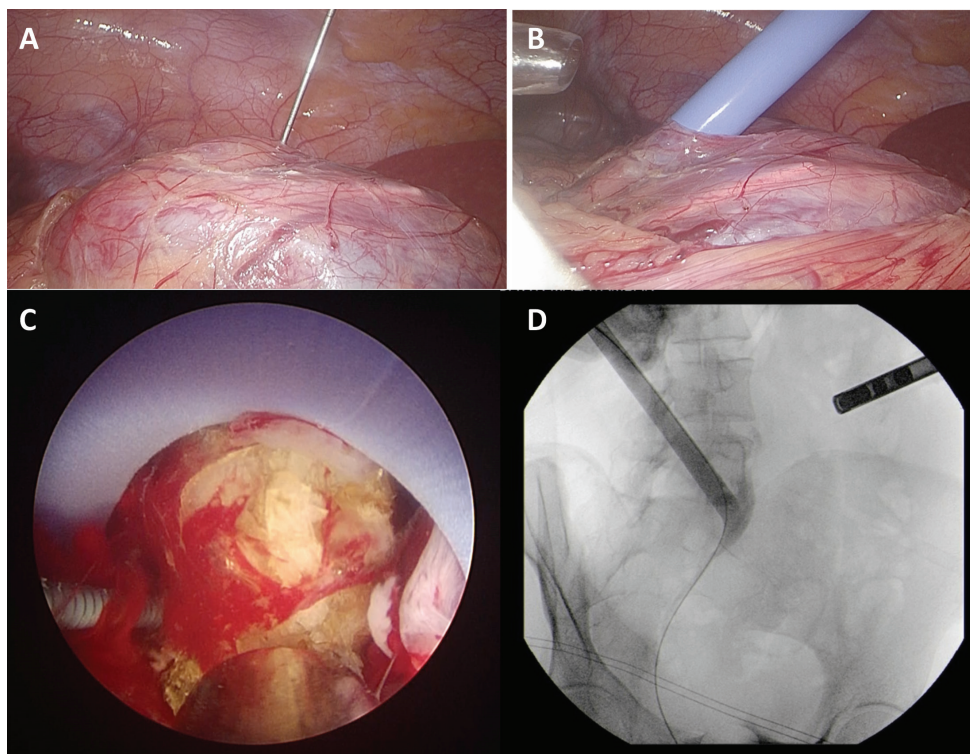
(a) Access on the middle segment of the right ectopic kidney via an 18-gauge Chiba needle (laparoscopic view), (b) 28 Fr Amplatz type renal sheath inserted after access and dilation (laparoscopic view), (c) 2 cm middle calyceal calculus fragmented with ultrasonic lithotripter, (d) Antegrade nephrostogram showing complete stone clearance
